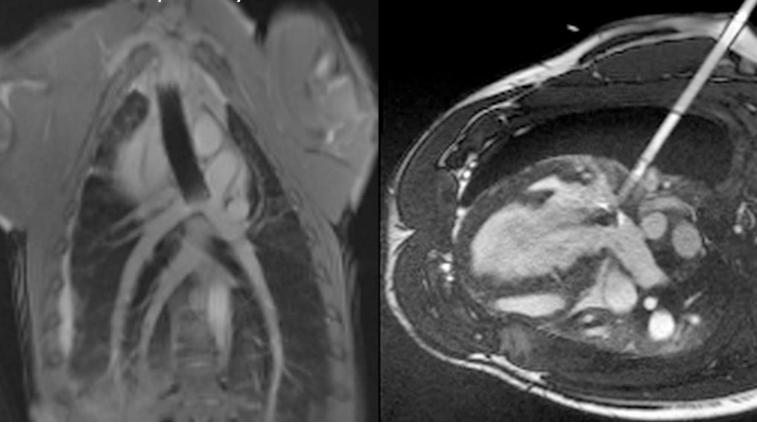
Real time MRI guided percutaneous cavopulmonary shunt and transthoracic left atrial access.
